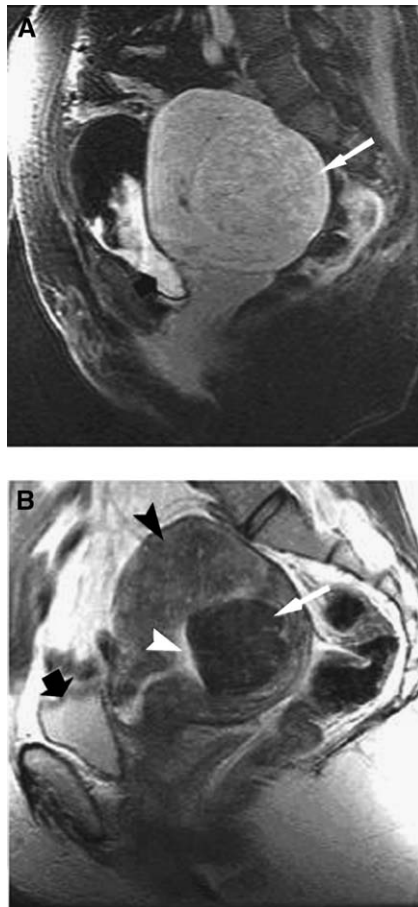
(A) Sagittal T1-weighted spoiled gradient echo image before embolization shows heterogeneous enhancement of the leiomyoma (*white arrow*). (B) Sagittal T2-weighted image of the uterus 5 months after embolization shows shrinkage and homogeneous low signal intensity of the leiomyoma (*white arrow*), (*top black arrow*, uterus; *left black arrow*, bladder). (From Mueller GC, Gemmete JJ, Carlos RC. Diagnostic imaging and vascular embolization for uterine leiomyomas. *Semin Reprod Med* 2004;22(2):135; with permission.)
